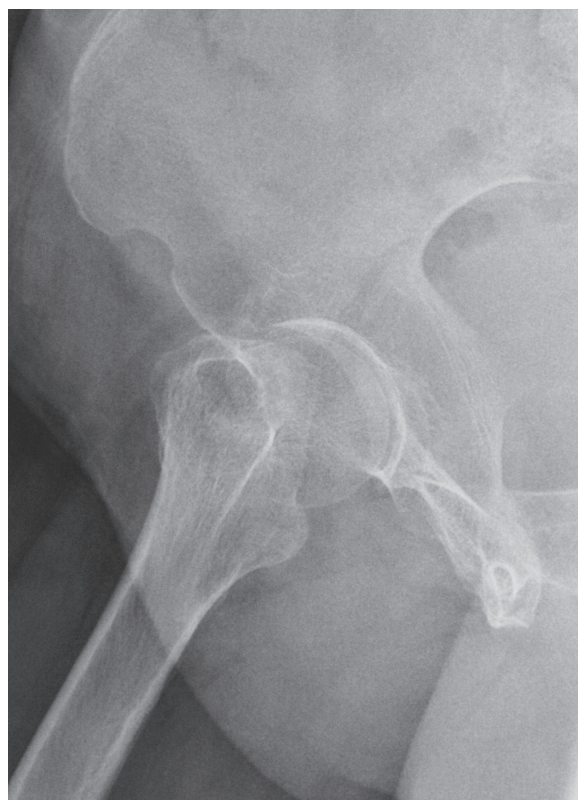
Lateral radiograph view of hip joint with different angulation of the fracture side.
